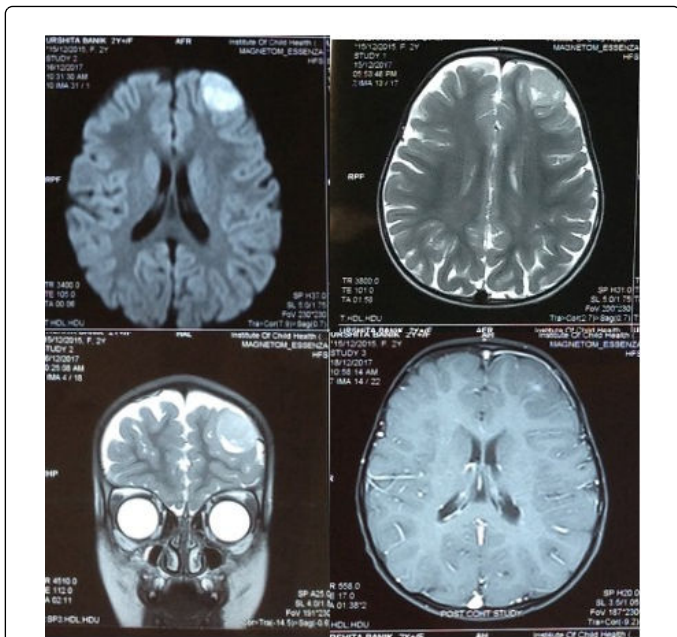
Showing MRI images pre-op, with Axial DWI in (A) demonstrating the altered density of the lesion, Axial T3n in (B), Coronal T2 in (C) both demonstrating the lack of water within the lesion hinting at a highly cellular tumor, and Axial contrast in (D) showing almost no enhancement.
